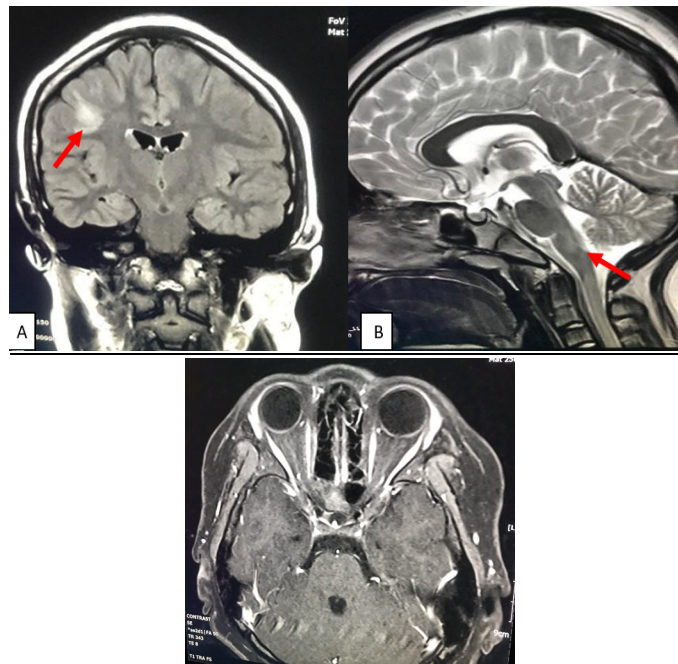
MRI showing (A) Multiple hyperintense white matter lesions seen at right parietal centrum semiovale. (B)Juxta cortical hyperintense lesions. (C)Minimal peripheral enhancement of the midportion of right optic nerve
